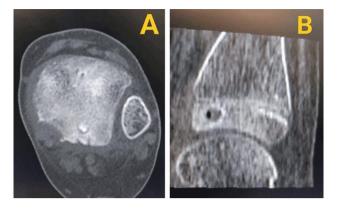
Computed tomography scan of left ankle in (A) axial and (B) sagittal cuts.
